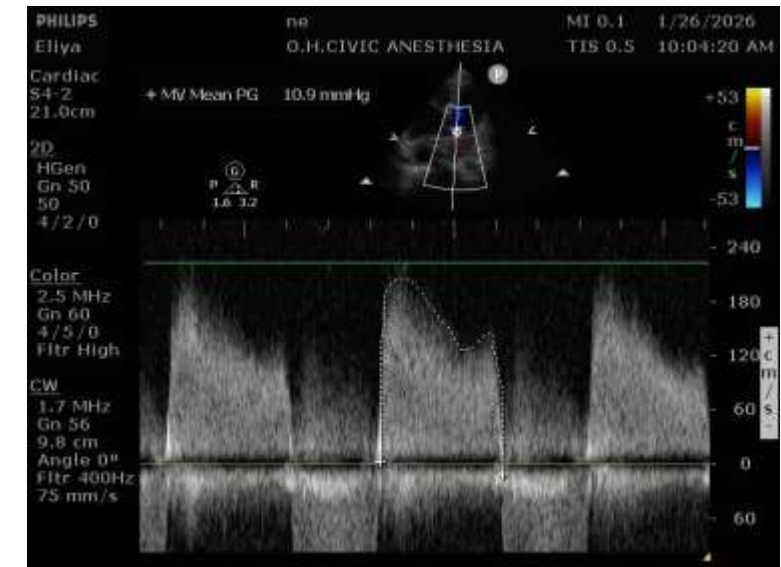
Continuous wave doppler revealing a decrease in the transmitral gradient after delivery and carbetocin injection.
